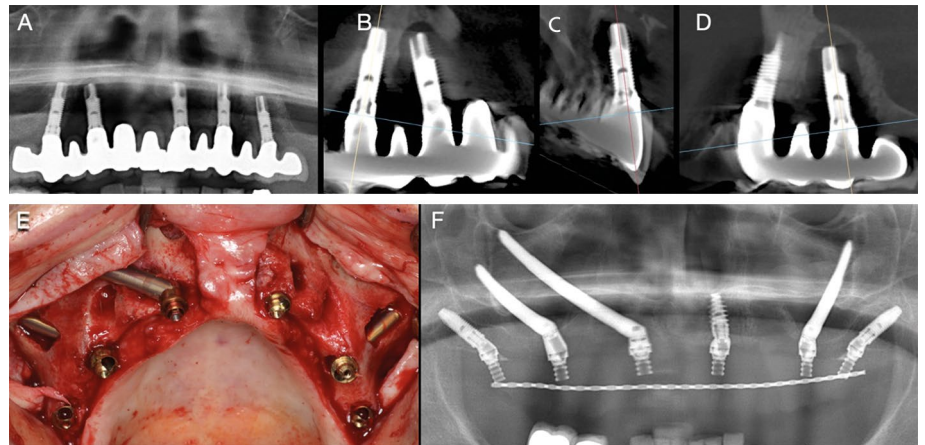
Panoramic radiograph (a) and cross sections (b, c, d) through each implant site show extensive peri-implant disease and multiple implant failures. Subsequent treatment is inevitably more complex, in this case necessitating reconstruction with a combination of dental and zygomatic implants as seen at the time of surgery (e) and in a subsequent panoramic radiograph (f). Patients need to be made aware of the requirement for ongoing maintenance and repair, with an appreciation of the longevity of a reconstruction, and the possible need for eventual replacement
